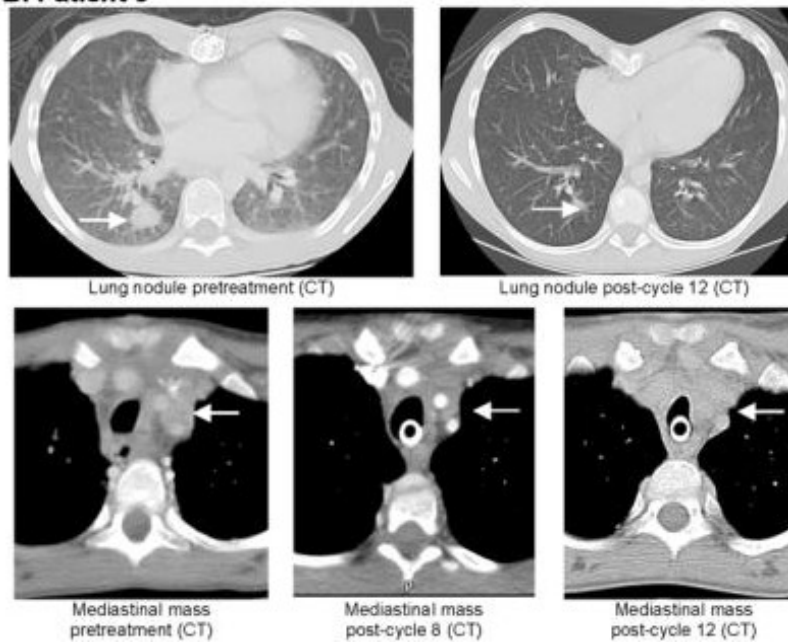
Radiographic Objective Responses in Children and Adolescents with MTC and MEN2B (116).
